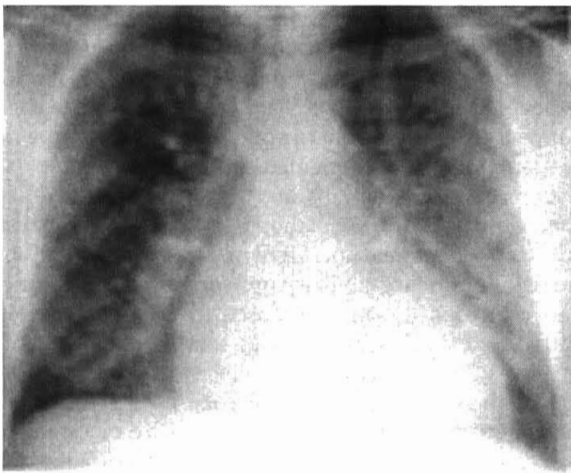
Chest radiograph of a patient with pulmonary edema.
